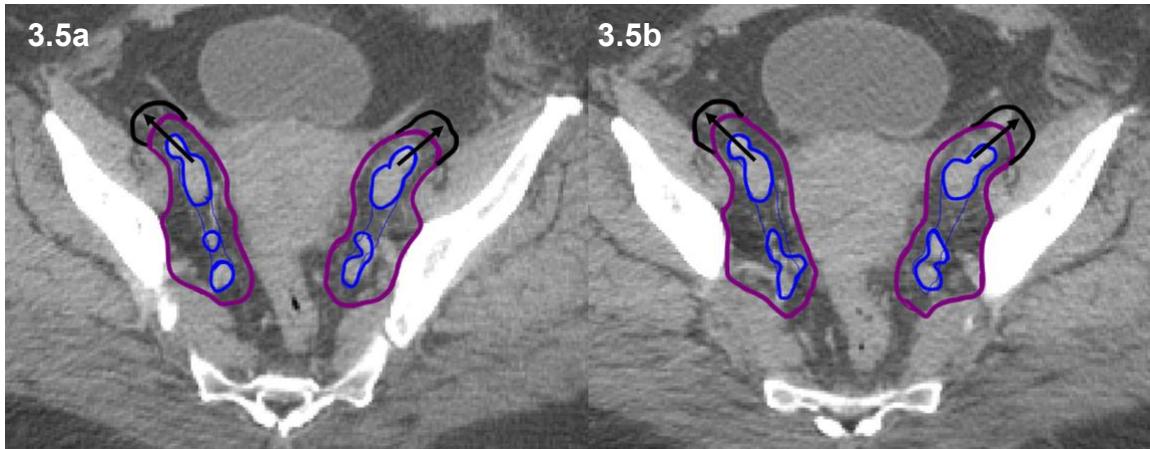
Axial CT in the region of the internal and external iliac vessels (blue) showing anteriolateral extent (arrowed) along the iliopsoas muscle to include lateral external iliac nodes
